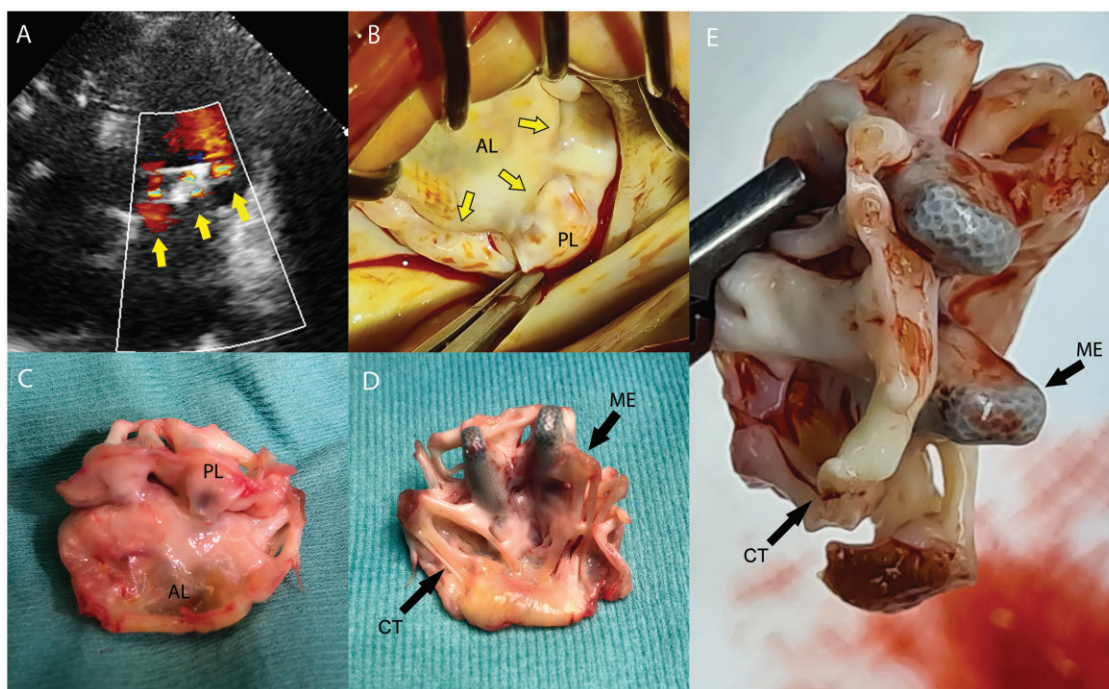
Preoperative echocardiographic 'triple-orifice' mitral valve (A) and intraoperative view from a left atrial approach (B). Surgical sample showing fusion of mitral leaflets (C) with chordae tendineae and MitraClip endothelialization (D and E). AL: anterior leaflet; CT: chordae tendineae; ME: MitraClip endothelialization; PL: posterior leaflet.
